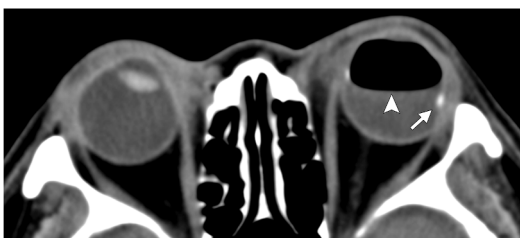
Axial CT orbits showing a left pneumatic retinopexy with gas-fluid level (arrowhead) and a left scleral buckle (arrow).
